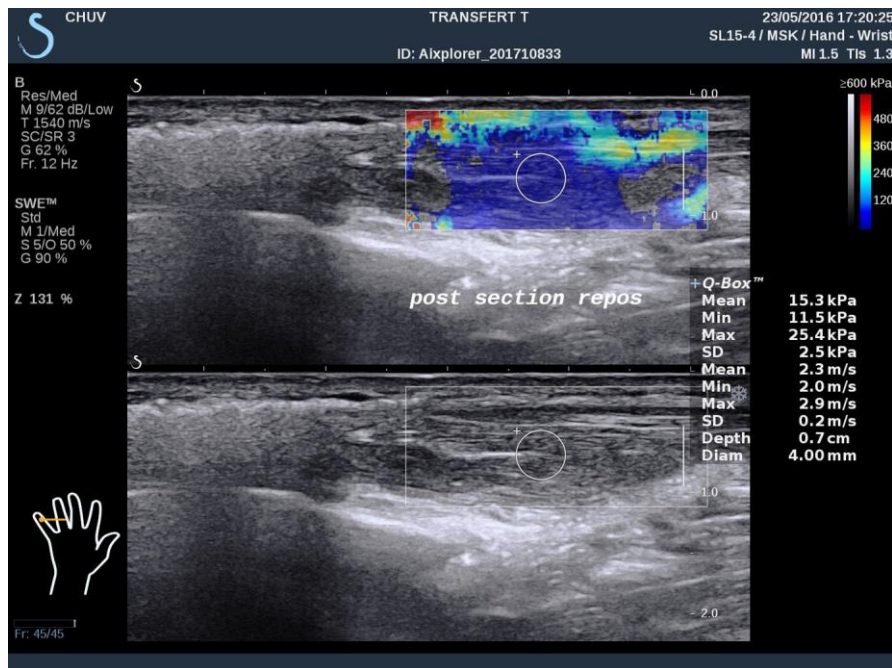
B-mode ultrasound (low) and elastographic (high) recording during the 4th stage of the transfer (S).
